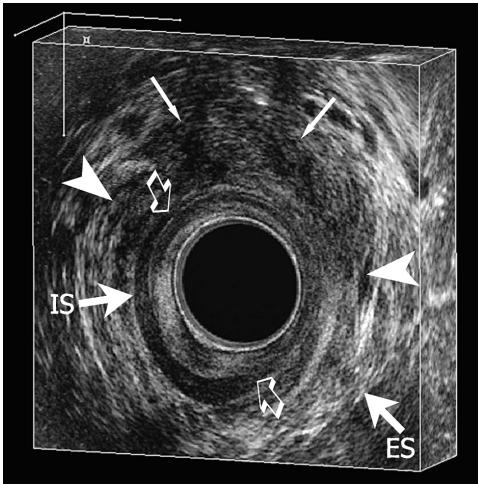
Three-dimensional endoanal ultrasonography at the mid-anal canal obtained from a 37-years-old woman demonstrating a large obstetric tear involving both the internal (open arrows) and external (arrow heads) anal sphincter after a complicated vaginal delivery visualized by discontinuity of the inner and outer sphincter ring. Scar tissue (thin arrows) of the external anal sphincter is depicted anteriorly by segments of very low reflectivity. The top of the figure is anterior.
